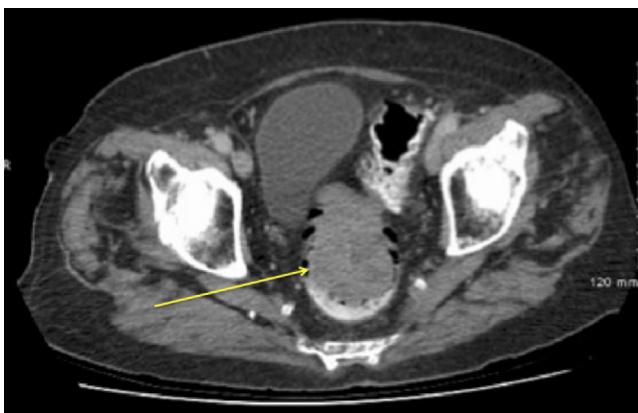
Axial CT pelvis post administration of IV and oral contrast, demonstrating an exophytic mass (Yellow arrow) involving the anterior aspect of the mid and upper rectum.
